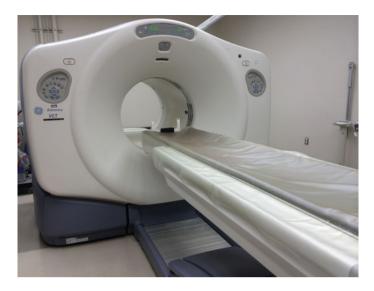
PET/CT scanner unit. Patient is placed on movable table in alignment with the central axis of the cylindrical scanner bore, with aligned sequential PET and CT scanners (note depth of machine bore)
